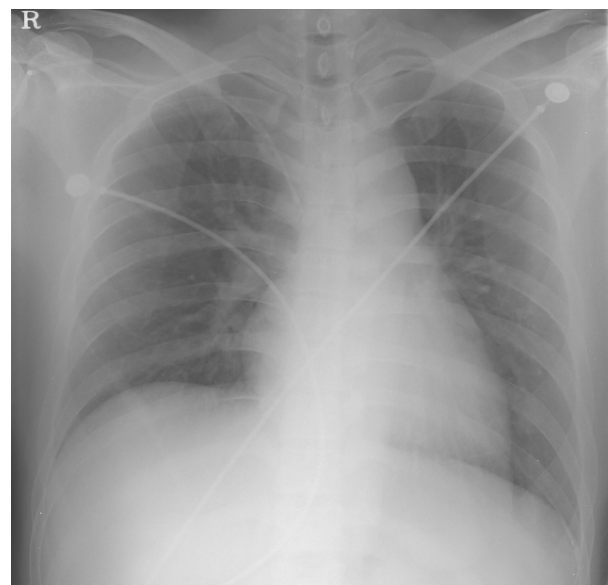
Chest X-ray (Admission day)
